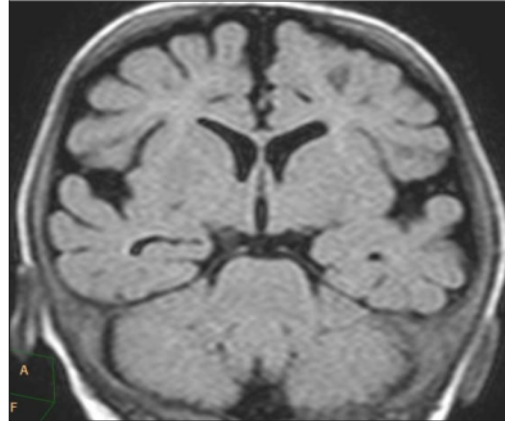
The Head MRI coronal view showing hypoplasia of corpus callosum
